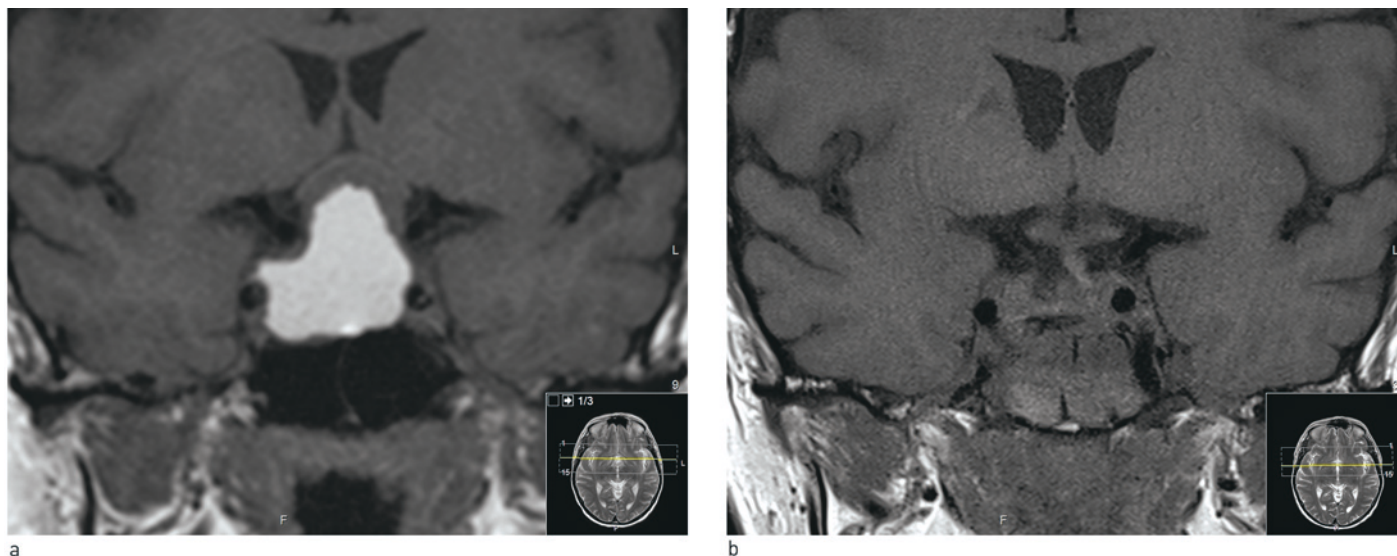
Coronal T1-weighted MRI images without contrast. a) Large opacity in sella turcica that extends up in the suprasella direction. The optic nerves and optic nerve decussations have been pushed upwards and are seen as a thin, half-moon shaped strip above the tumour. The tumour has a solid component with a low signal just under the optic paths. The large cystic component is seen with a high signal and parallels the internal carotid artery bilaterally. b) Post-operative status. Tumour was removed transphenoidally. There are copious blood products in the sphenoidal sinus. The optic nerves and optic nerve decussations are now lying free and their thickness has normalised. Under them the pituitary stalk is seen in the mid-line with a slight deviation to the left (right in the picture)
